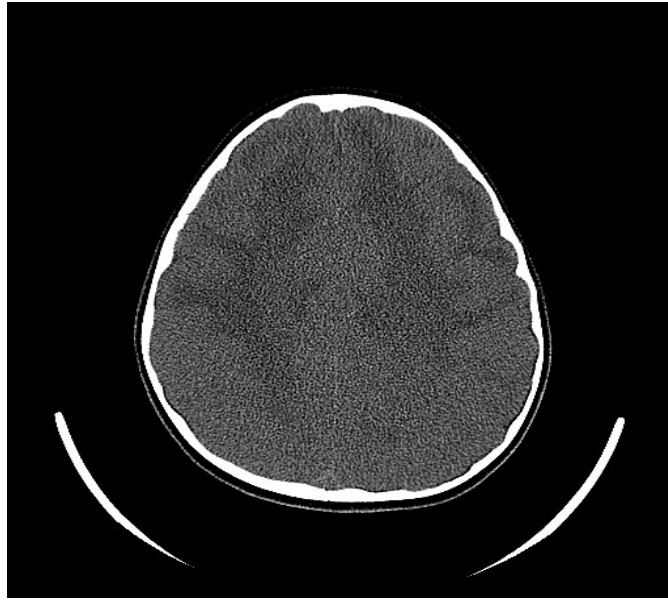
Noncontrast head CT exhibiting bilateral symmetric diffuse deep white matter hypodensities, more marked in the frontal lobes.
